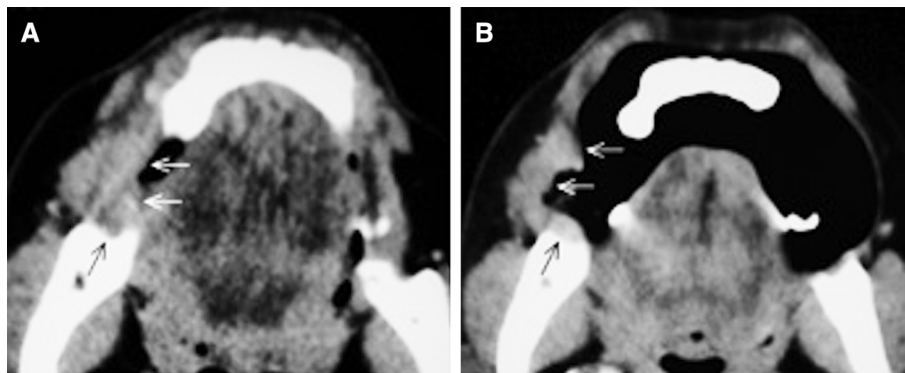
Contrast-enhanced computed tomography images of a 55-year-old woman, referred for a painful, bleeding buccal lesion. (A) Although the mass (black and white arrows) can be identified on the images obtained during a routine scan, it is not possible to determine from which mucosa the mass is arising. (B) On images obtained with the puffed-cheek technique, the tumour is seen to originate from the right buccal mucosa (white arrows), with invasion into the retromolar trigone (black arrow). There is a remarkable loss of pliability due to peritumoural fibrosis and infiltration of the buccinator muscle.
